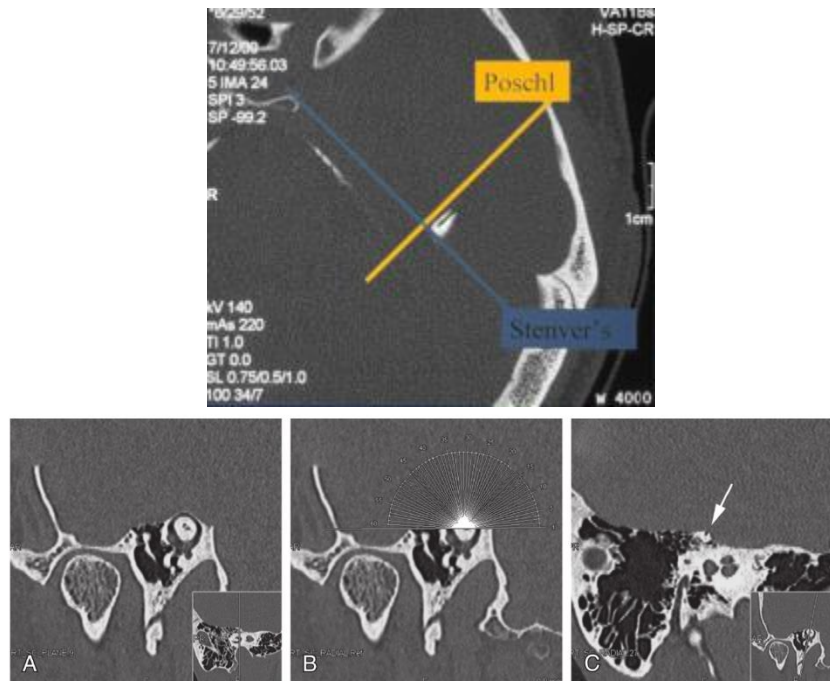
Computed tomography (CT) of the right superior semicircular canal demonstrates dehiscence. A, CT is reconstructed in the plane of the torus of the right superior canal (SC). B, The center of the SC is identified, and radial orthogonal reconstructions are performed at 3-degree intervals. C, The radial reconstructions are sequentially examined along the course of the SC, and dehiscence in the canal is identified if bone does not appear to completely cover the canal (white arrow). Inset images in A and C show the perpendicular view.
